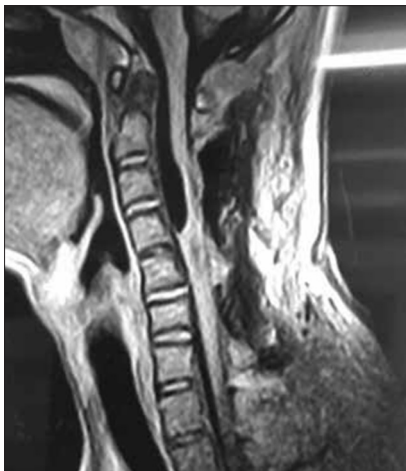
T1 magnetic resonance imaging sagittal – band from caudal of C4 vertebral body to the middle of C4 vertebral body
